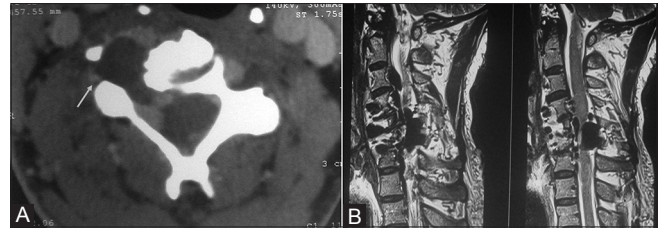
(A and B): (A) CT scan demonstrating defect in the pedicle due to erosion (B) MRI demonstrating the fistula with high flow voids with features of venous hypertension as suggested by high T2 signals in the cervicomedullary junction in the second panel
